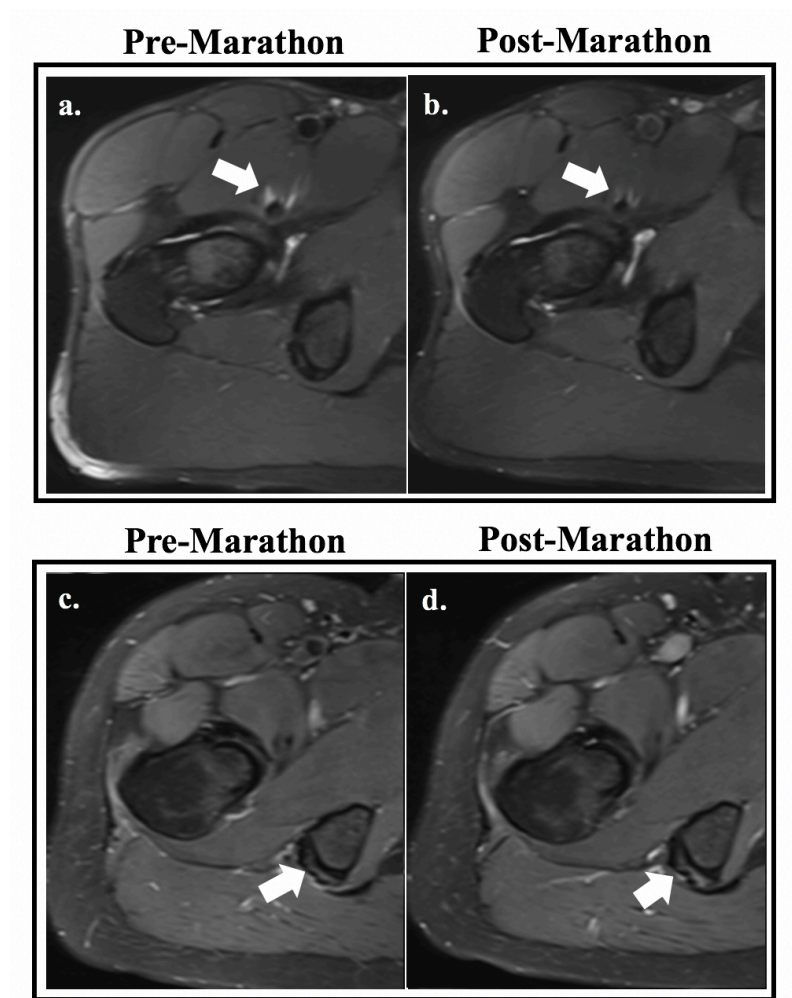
Axial Dixon MR images of 2 participants showing tendinosis before the marathon and no worsening after the marathon. Participant 1 (a – pre-marathon; b – post-marathon) had psoas tendinosis (arrowed). Participant 2 (c – pre-marathon; d – post-marathon) had hamstring tendinosis (arrowed). SHOMRI grading system was used; SHOMRI, Scoring hip osteoarthritis with MRI.
